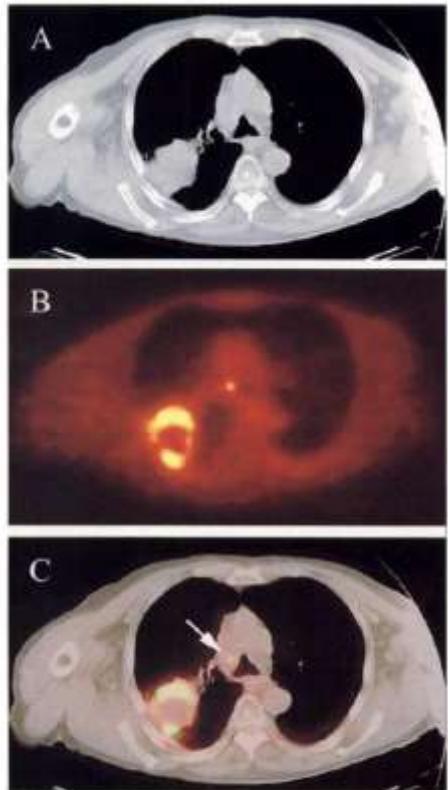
A 78-y-old man with squamous cell carcinoma of the lung. (A) Large isodense mass seen on CT appears on (B) PET scan as a hypermetabolic rim of increased FDG uptake, with necrotic center. (C) Fused image shows good alignment of 2 modalities. Lymph node in mediastinum (arrow) also demonstrated increased FDG uptake.
